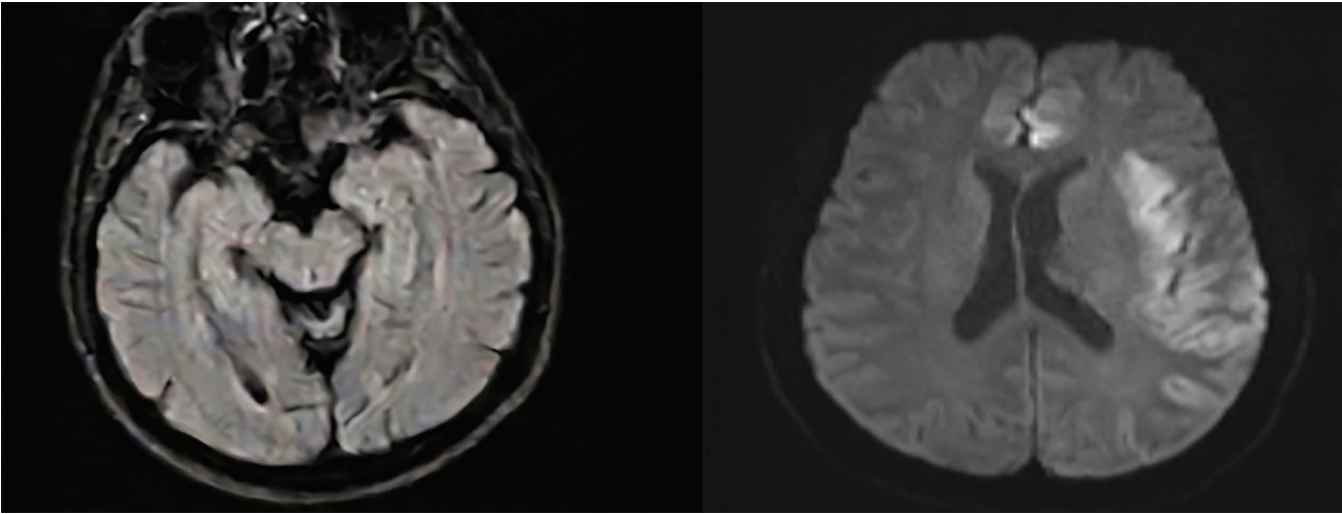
Representative cranial magnetic resonance imaging findings. Autoimmune encephalitis: FLAIR hyperintensity in the mesiotemporal region consistent with limbic encephalitis. Viral encephalitis (HSV): frontotemporal signal abnormality with restricted diffusion on DWI
